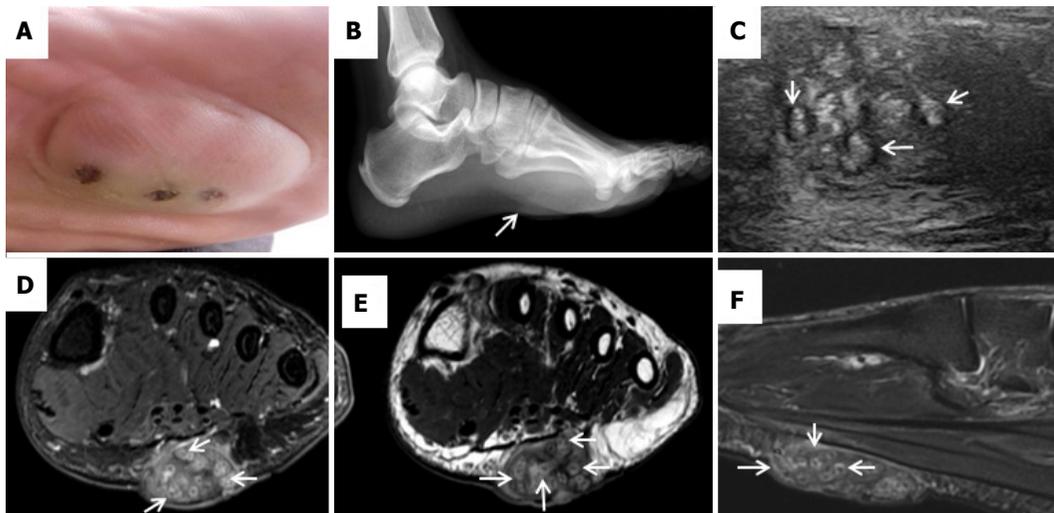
Eumycetoma at the plantar aspect of foot. (A) A protuberant swelling at plantar aspect of foot with few encrusted sinuses. (B) Lateral radiograph of the foot appears normal except a soft tissue density shadow on the plantar aspect (arrow). (C) On high resolution ultrasound, multiple clustered lesions are noted, which have hypoechoic periphery and hyperechoic center. (D–F) Axial STIR (D), T2WI (E), and Sagittal STIR (F) MRI images show multiple hyperintense lesions with central hypointense dots (white arrows) showing typical “dot in circle” sign in the subcutaneous plane.
